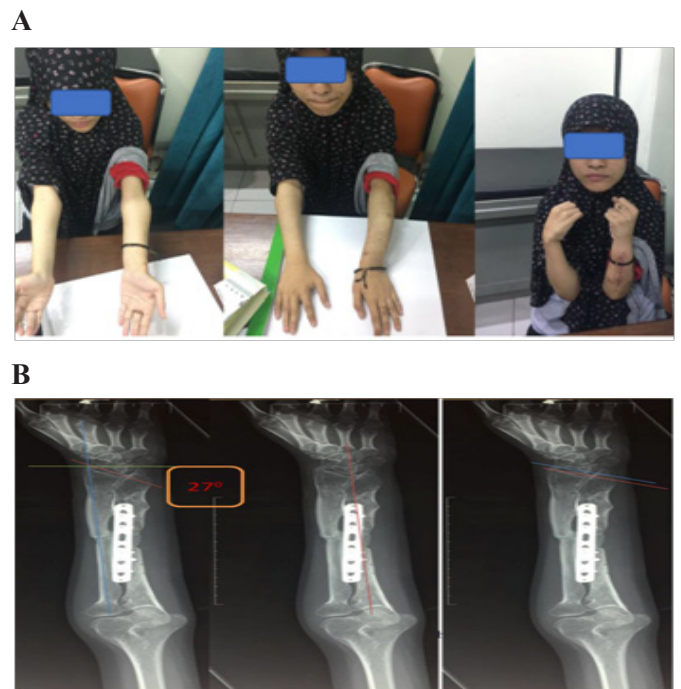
Clinical and radiographic photo of the right forearm in patient 3 A. achieved full range of flexion elbow and pronation after the operation with no complications.. B. Radiographs after the operation with all of the parameter was normal limit
